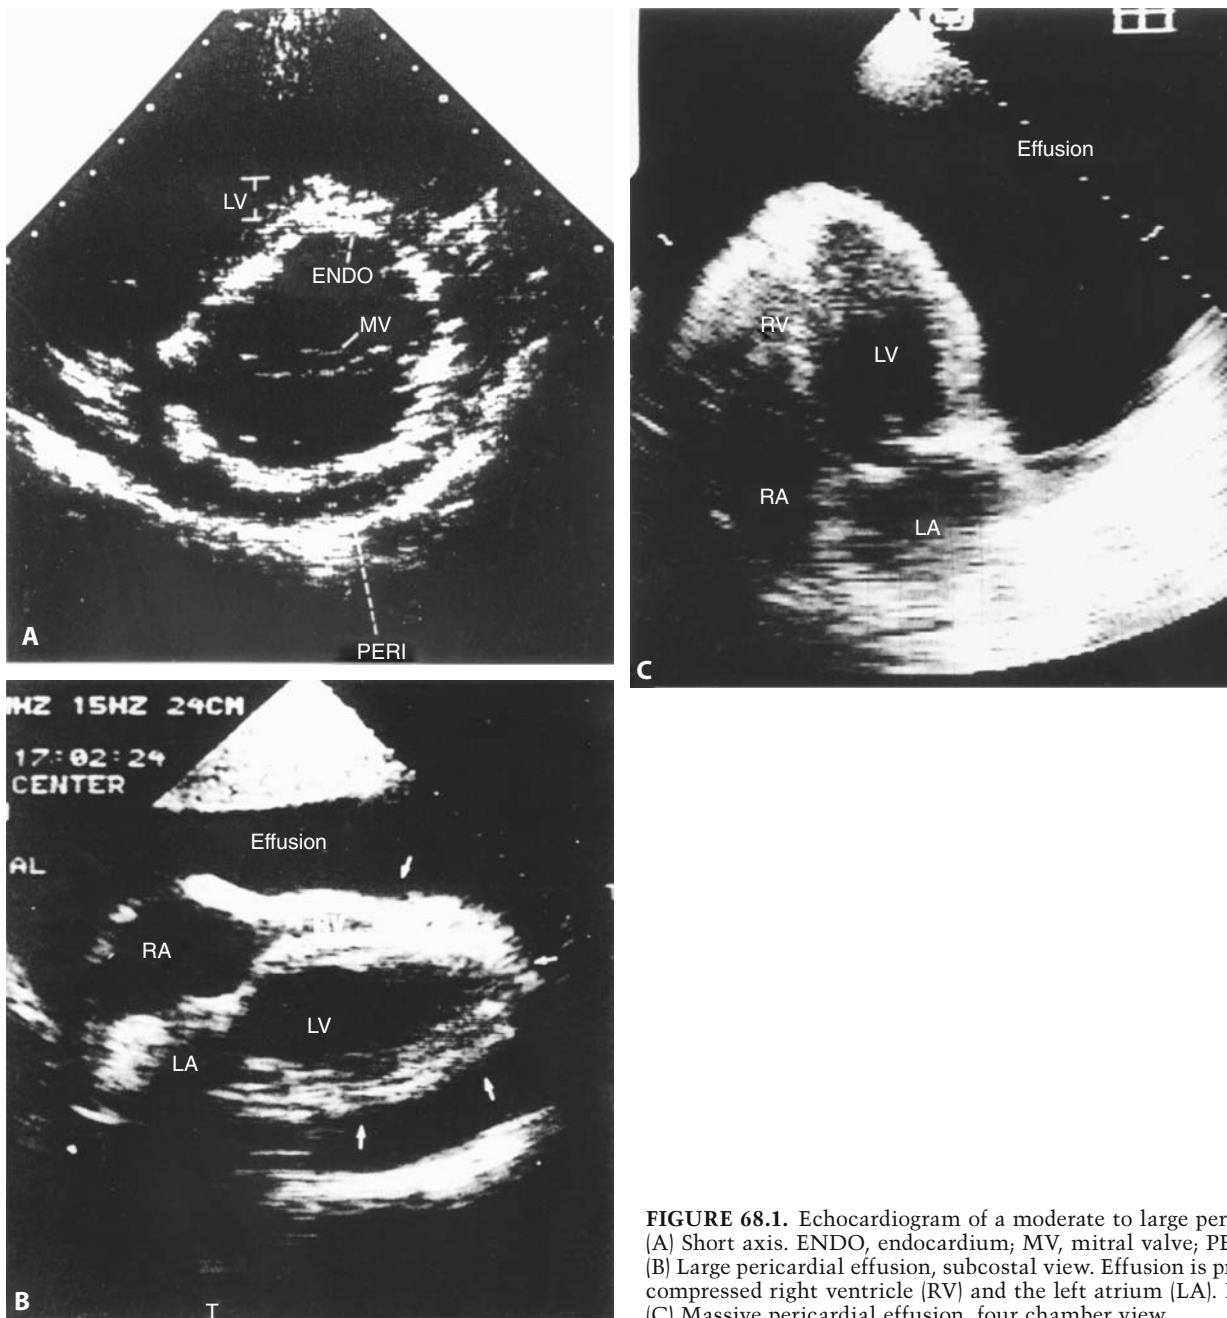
Echocardiogram of a moderate to large pericardial effusion. (A) Short axis. ENDO, endocardium; MV, mitral valve; PERI, pericardium. (B) Large pericardial effusion, subcostal view. Effusion is present behind the compressed right ventricle (RV) and the left atrium (LA). LV, left ventricle. (C) Massive pericardial effusion, four chamber view.
